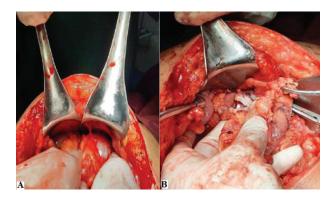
Peritoneal cerebrospinal fluid pseudocyst as depicted on CT scan in Figure 3: (A) pseudocyst before aspiration; (B) pseudocyst after aspiration of 750 ml of fluid, the distal shunt was identified. Image credits: Risfandi M, Celia C, Shen R. Abdominal wall pseudocyst as a complication of ventriculoperitoneal shunt insertion: a case report. Pan Afr Med J. 2022 Jan 10;41:23. doi: 10.11604/pamj.2022.41.23.29426. Reused under the terms of the Creative Commons Attribution International 4.0 License (https://creativecommons.org/licenses/by/4.0/)
